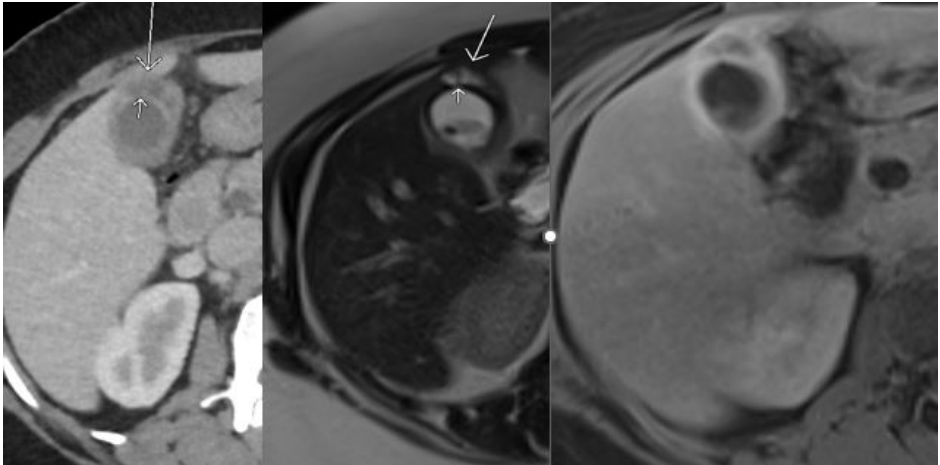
Gallbladder perforation in a 42-year-old male patient. A pericholecystic abscess (long arrow) is seen as a focal defect in the gallbladder wall (short arrow) on axial CT (a) and T2-weighted (b) images (long arrow). In the contrast-enhanced MRI sequence, contrast enhancement is observed in the gallbladder wall and around the abscess.
